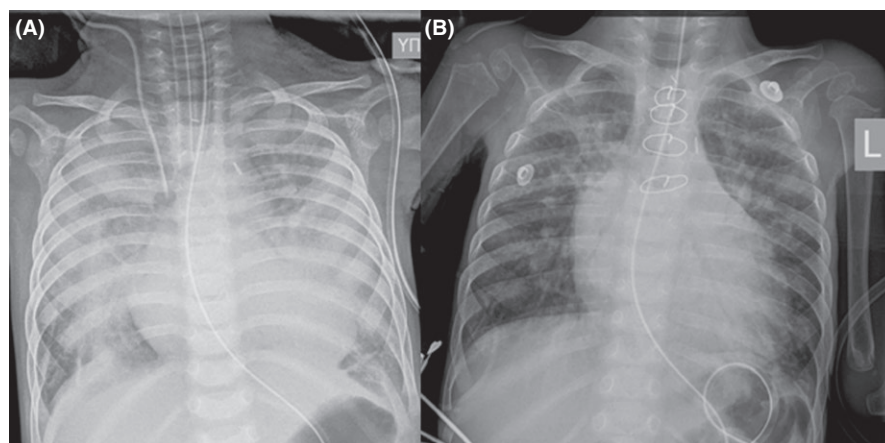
Chest X-ray showing the pulmonary edema (A) and the improvement on the postoperative day 6 (B)
